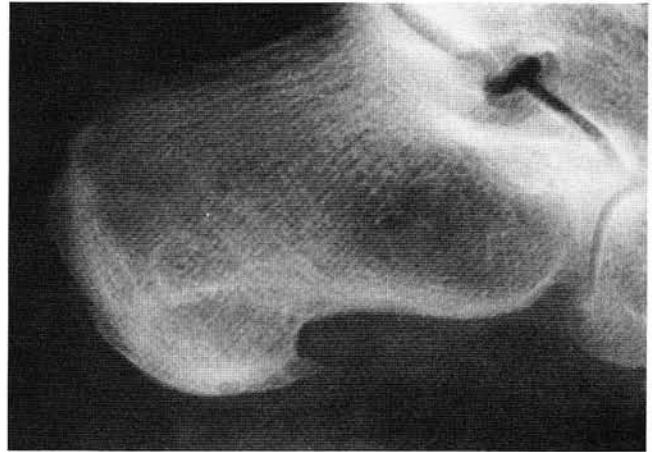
Lateral foot radiograph showing plantar heel spur.
